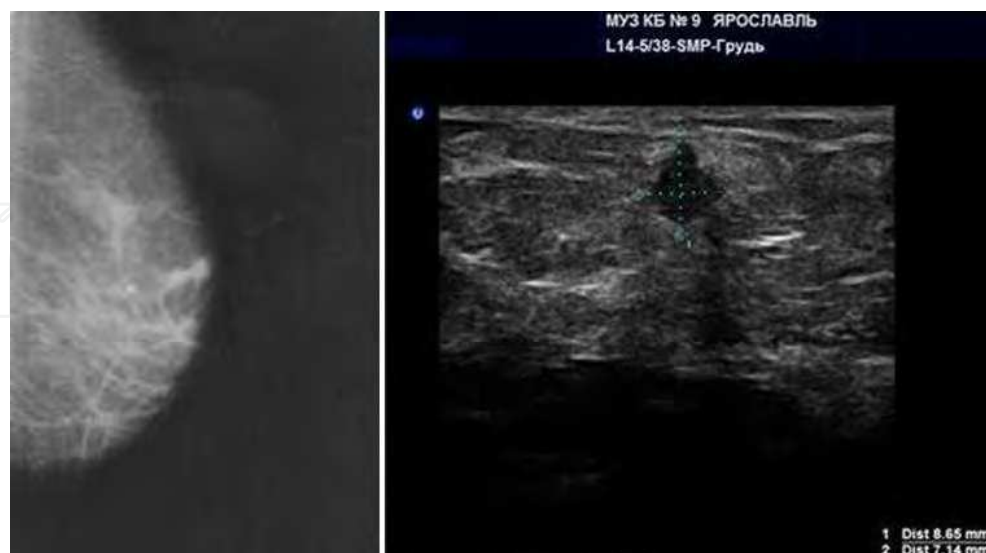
Roentgenogram (left): fibro-fatty involution. In upper-outer segment there is observed a lesion up to 1 cm in size with a radiant contour. Ultrasound (right): The structure of parenchyma with adipose lobules and connective tissue layers. An inhomogeneous 8x7 mm lesion of irregular shape is located at 28 mm distance from the nipple and at 12 mm depth.
